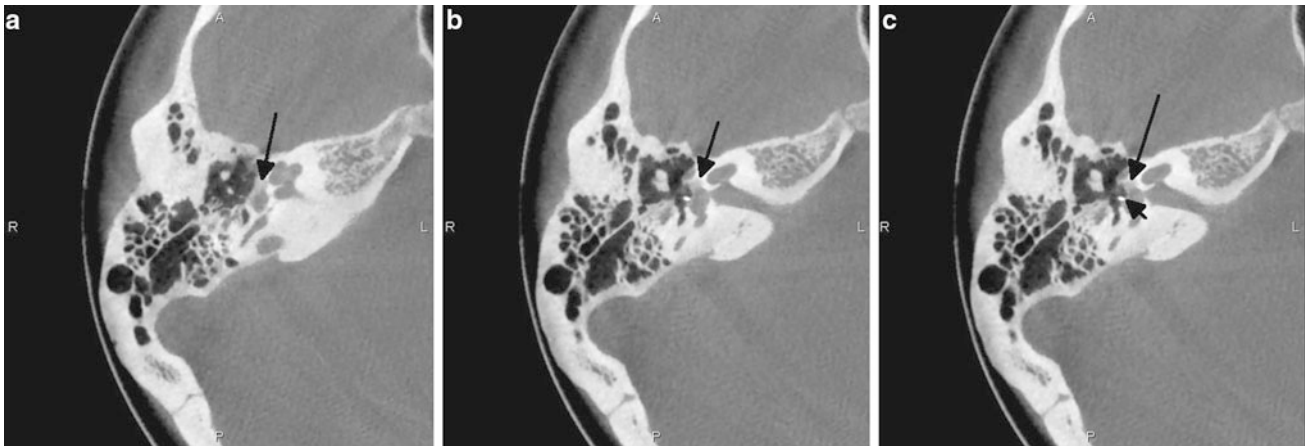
On these axial CBCT images (a–c) of the right middle ear, a hypodense focus of otosclerosis is nicely depicted in the region just
